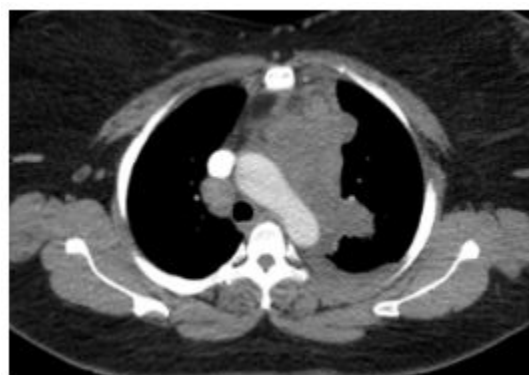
CT of Large irregular solid mass in superior mediastinum with mediastinal and hilar lymphadenopathy.
